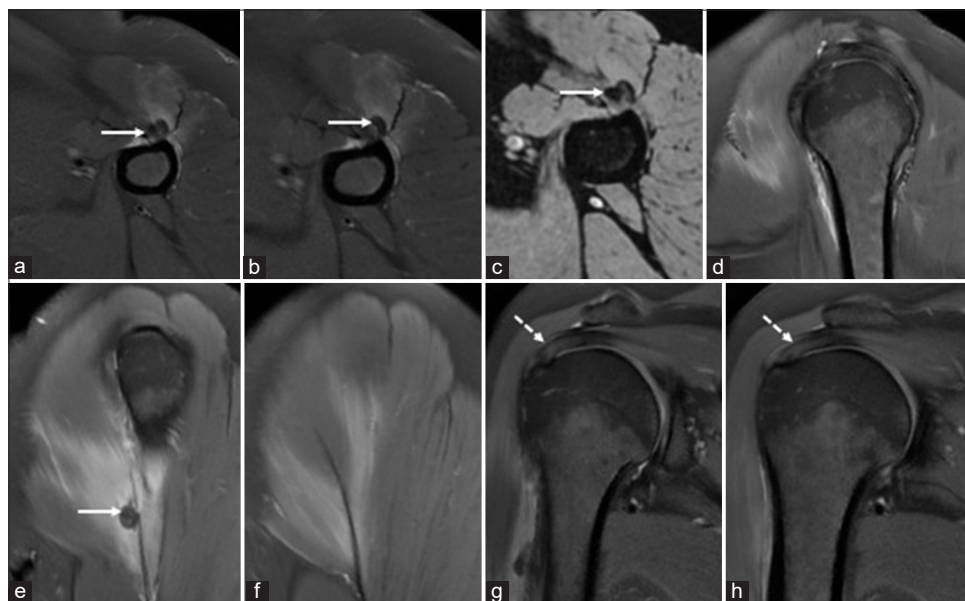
Magnetic resonance (MR) imaging of the left shoulder and upper arm. (a and b) axial proton density fat-saturated (PDFS) MR images reveal calcification (white arrows) towards the insertion of pectoralis major tendon into the humerus appearing hypointense on all sequences. Edema is seen in the surrounding tendon and soft tissues as well as feathery myofascial edema in the distal anterior fibers of the deltoid muscle. (c) Axial gradient image showing prominent blooming at the site of calcification (white arrow). (d, e and f) Serial sagittal PDFS images from medial to lateral showing calcification (white arrow) at the insertion of pectoralis major tendon into the humerus with edema in the surrounding tendon and soft tissues as well as feathery myofascial edema in the distal anterior fibers of the deltoid muscle. (g and h) coronal PDFS images showing intrasubstance hyperintense signal in the distal supraspinatus tendon, suggesting mild tendinosis (dashed white arrows).
